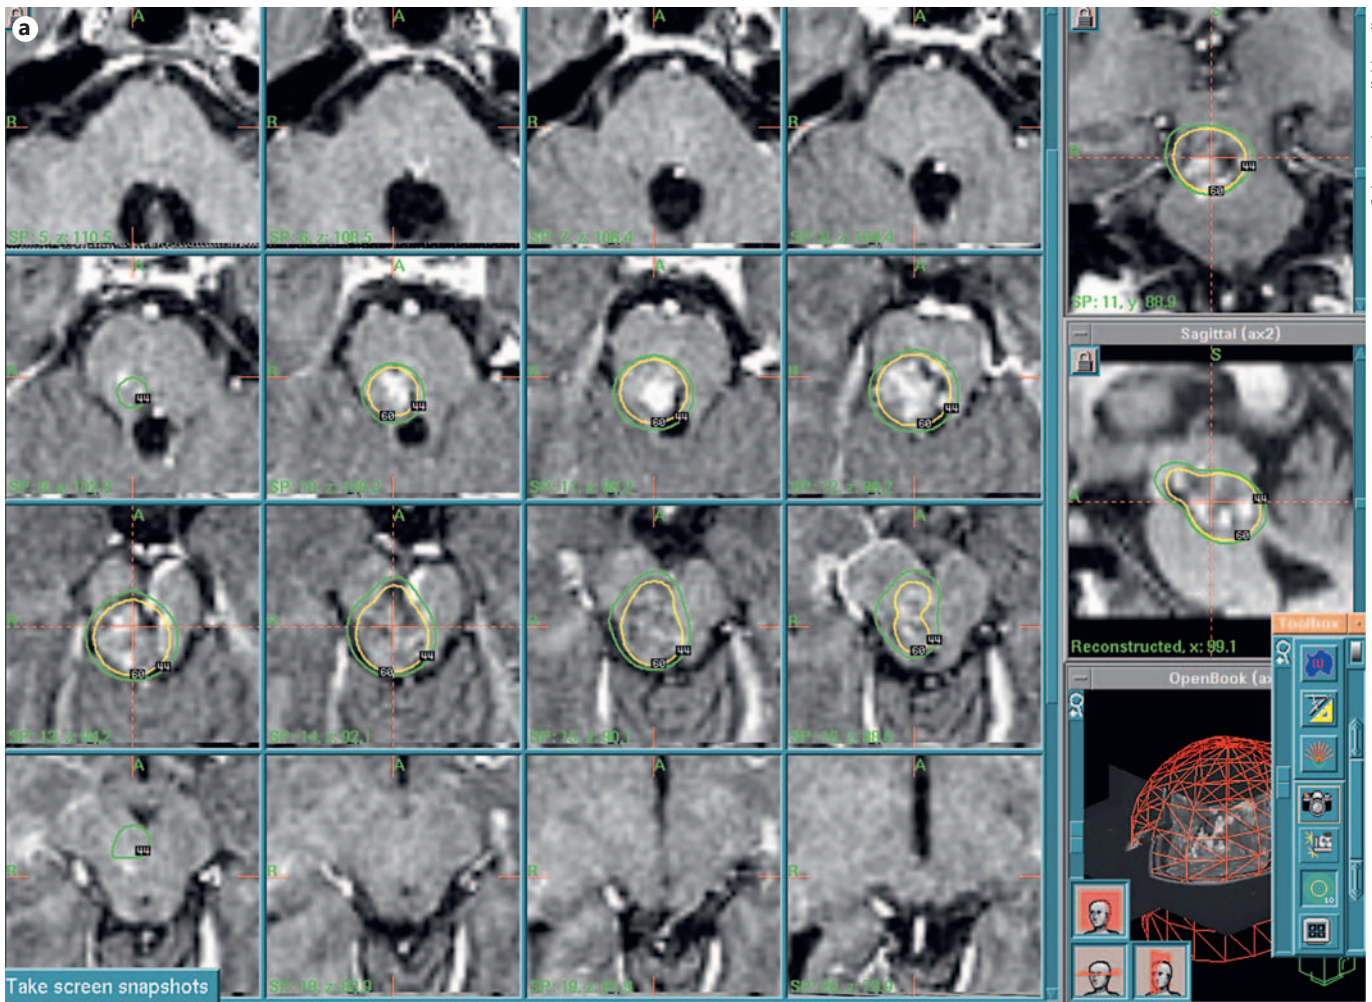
Example of treatment planning and important lesion volume reduction in imaging follow-up of 1 patient. a Isodose treatment planning. b Axial T2-weighted magnetic resonance image showing pons CM before treatment. c Axial T2-weighted magnetic resonance image showing pons cavernous malformation after treatment.
